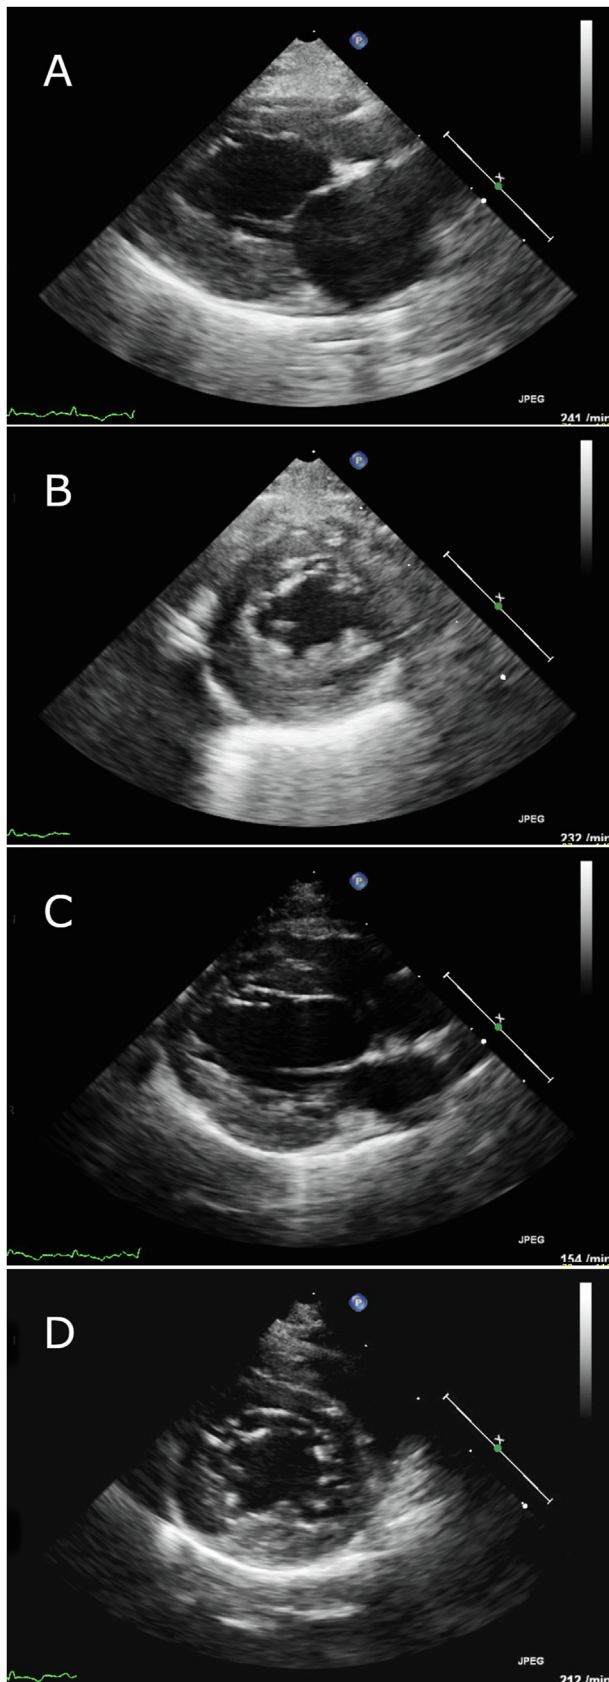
A–D Right parasternal long-axis and short-axis views at end-diastolic frames at initial presentation
